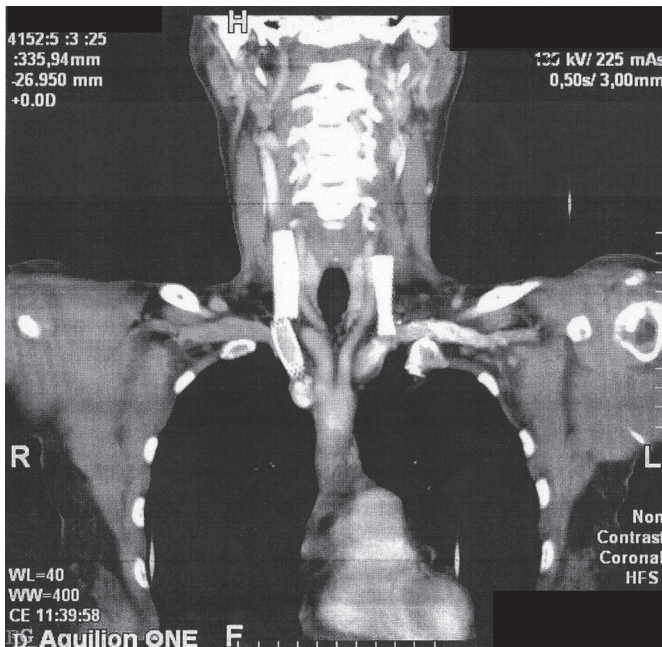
CT phlebography showed on the right side dislocation of proximal stent from jugular vein to brachiocephalic vein and partially to superior vena cava and dislocation of distal stent downwards as well, without signs of thrombosis. Thrombosis of stent was found on the left side.
